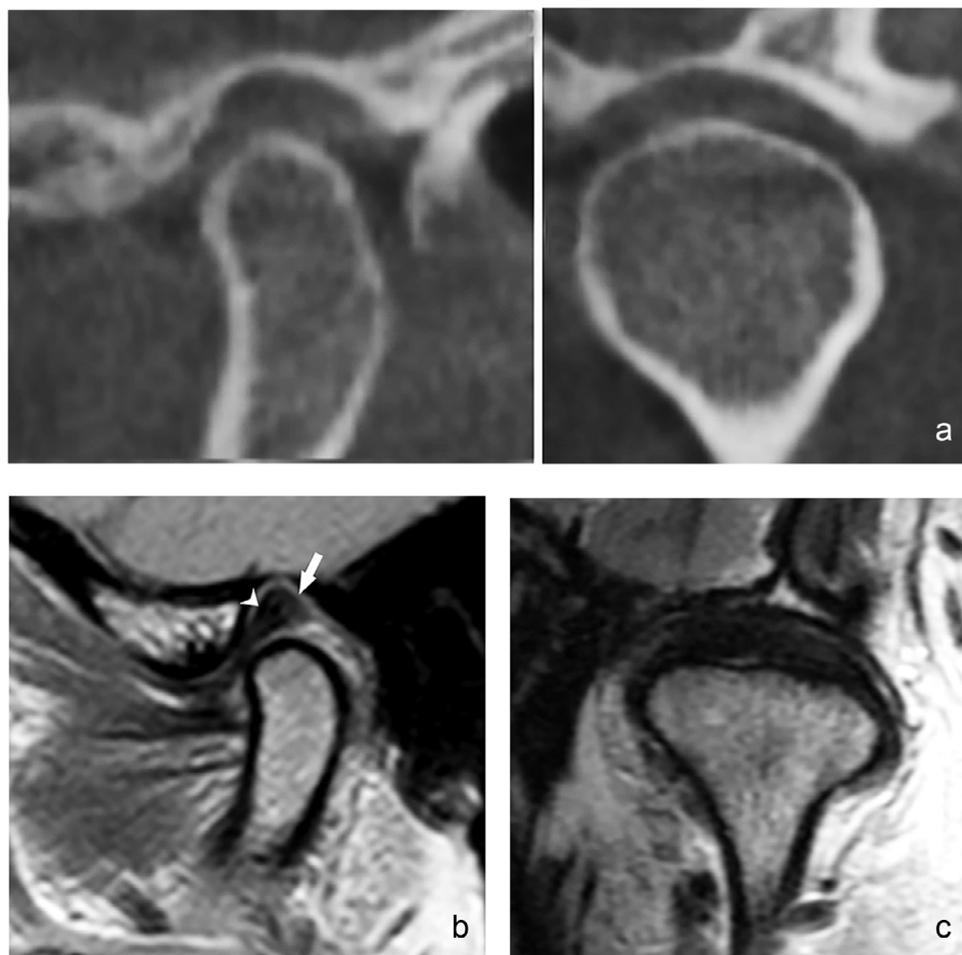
CBCT and MRI Axially corrected sagittal and coronal views show the normal anatomy of the TMJ. (a) On CBCT or CT: The osseous components are rounded and form an incongruent articulation. The condylar articular cortex is very thin in an adult condyle. The marrow spaces are uniform and not sclerotic. The normal disc space in the sagittal plane should reflect the bow-tie shaped disc that is interposed between the articular surfaces, and on the coronal should reflect the crescent shape of the posterior band of the disc. (b) Sagittal MRI, the posterior band of the disc sits at the 12 o'clock position on the condyle (arrowhead). The intermediate zone is between the incongruent articulations and the anterior band sits on the lateral pterygoid muscle fibers. The IPA (white arrow) is attached to the posterior band of the disc. The marrow spaces are homogenous and are bright on T1 and intermediate on T2. The cortical outlines are uniform and continuous. (c) On the coronal MRI, the posterior band of the disc resembles a crescent and sits evenly superior to the condyle, tapering toward the poles and attaching to the neck of the condyle with the lateral and medial collateral ligament.
